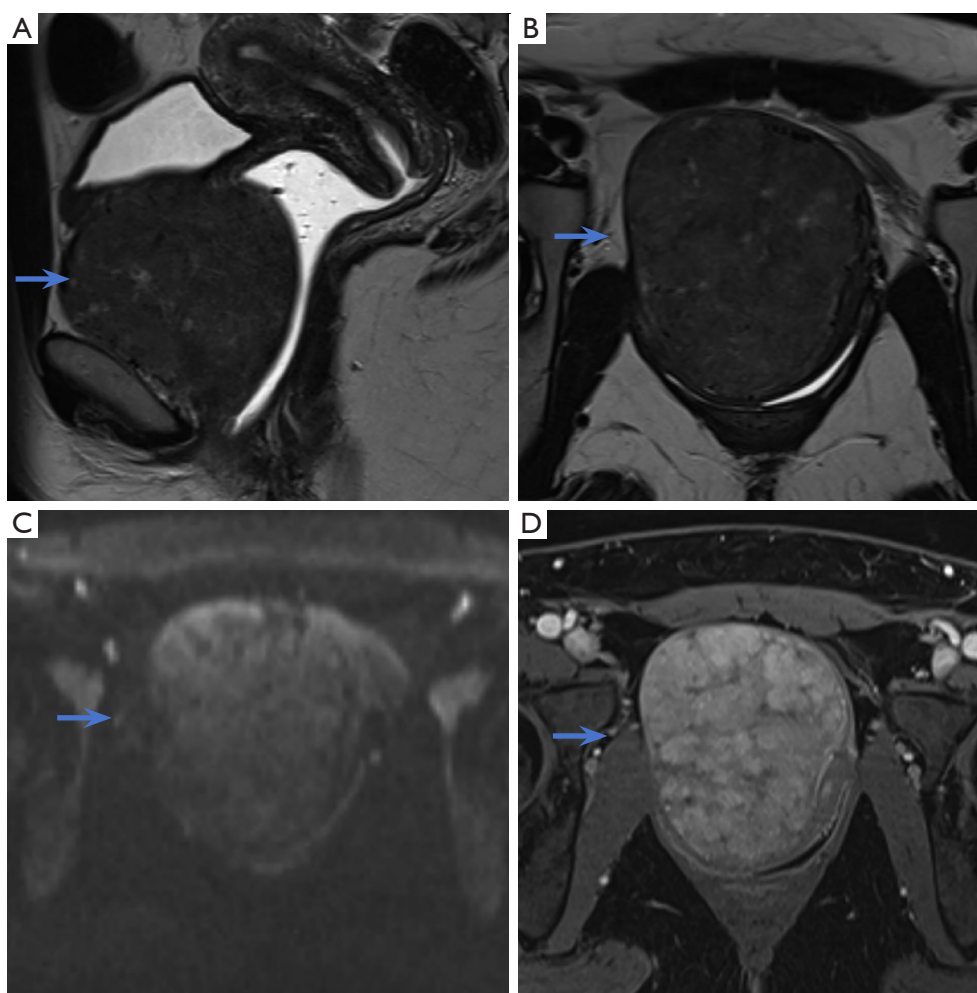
Urethral leiomyoma. VSD-enhanced pelvic MRI shows a well-defined mass (blue arrows) in the proximal right urethra, displacing the urethra leftward and vagina posteriorly. Slightly hypointense on T2 (A,B), with restricted diffusion (C) and heterogeneous contrast enhancement (D). MRI, magnetic resonance imaging; VSD, vaginal saline distension.
